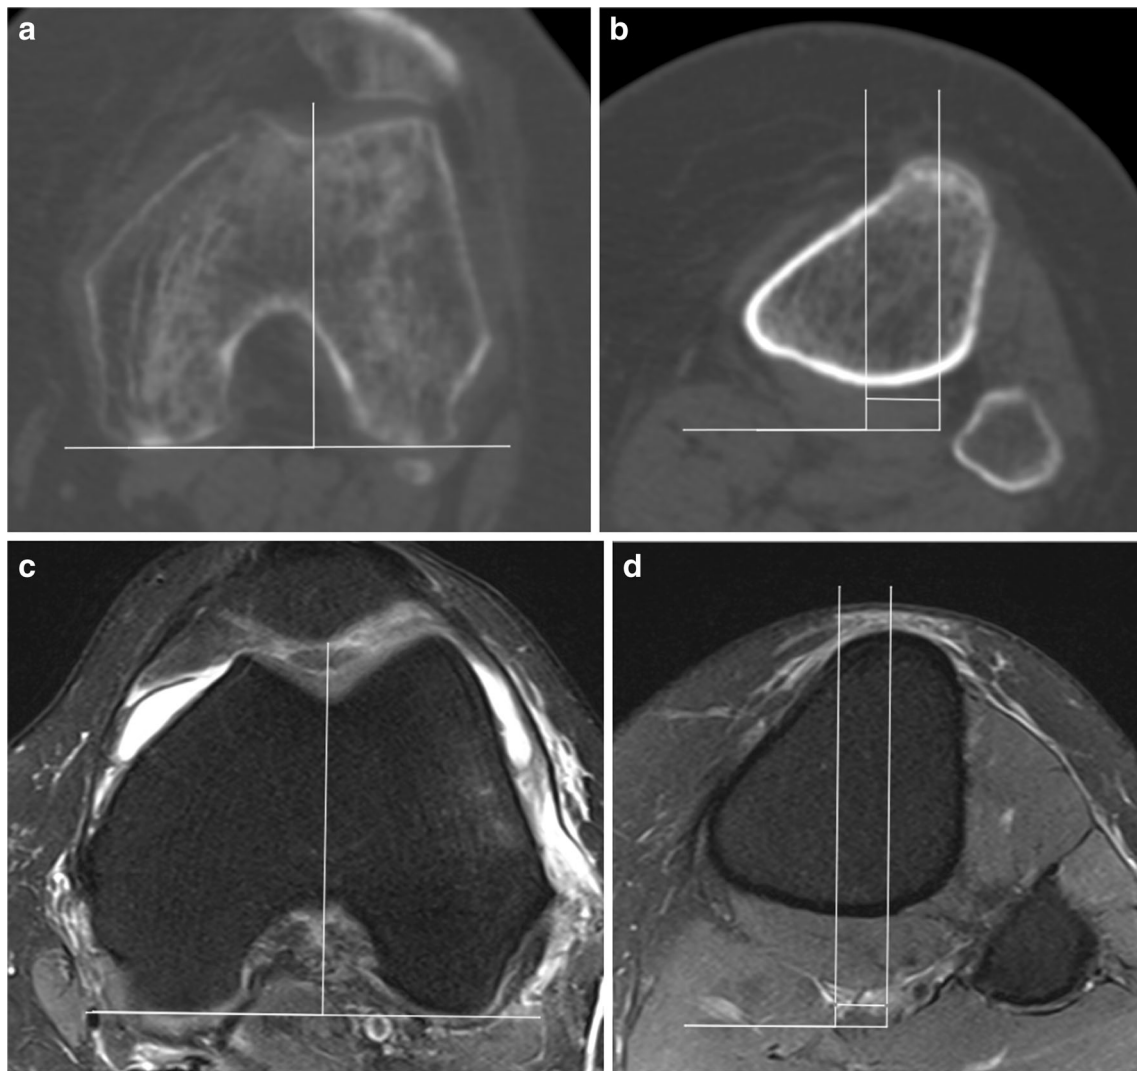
TT-TG distance on CT and MRI (images from different patients). *a* Osseous and osseous trochlear landmarks on CT; *b* osseous, osseous trochlear, and TT landmarks and the TT-TG distance determined on CT; *c* osseous and osseous trochlear landmarks on MRI; *d* osseous, osseous
